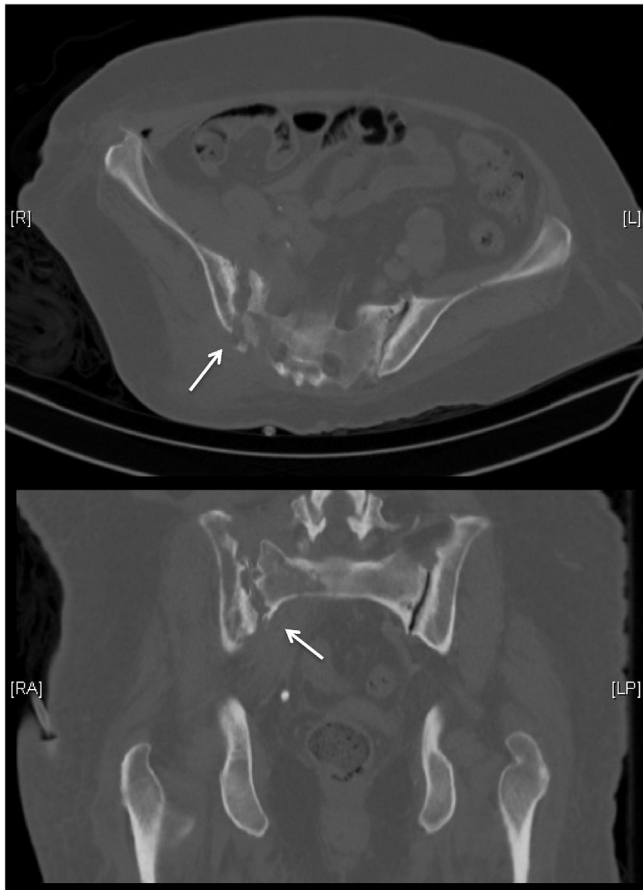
Axial and coronal sections of contrast enhanced CT scan of the pelvis (bone window) showing erosion with sclerosis involving the articular surface of right sacroiliac joint (SIJ).
